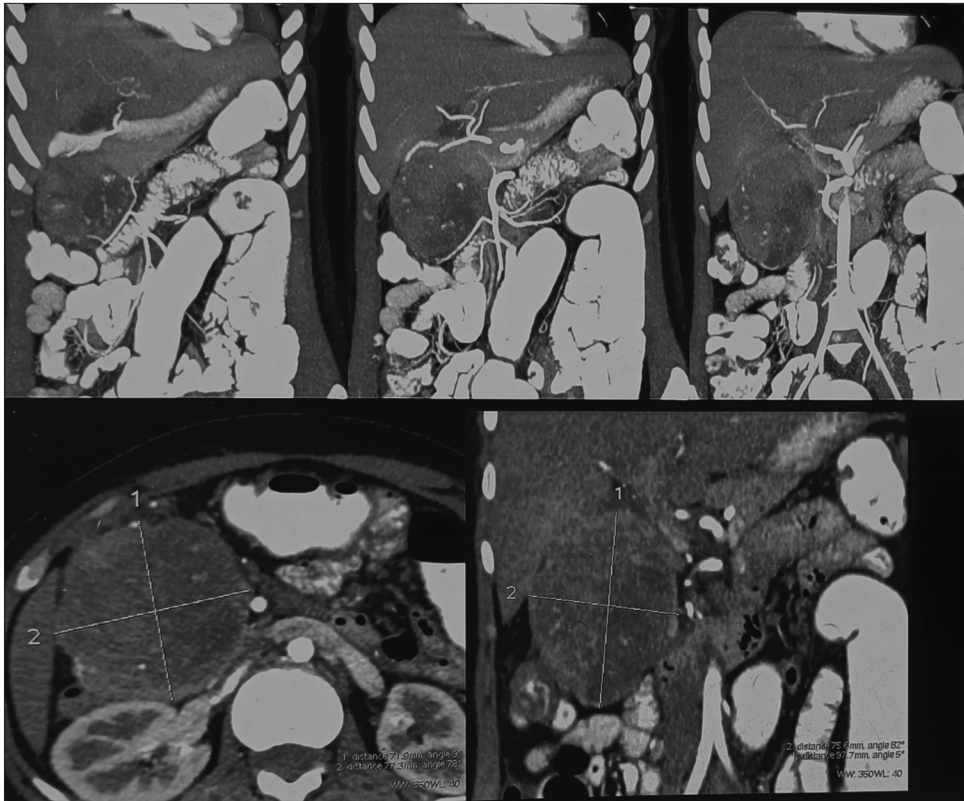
Contrast-enhanced computed tomography image, showing well-encapsulated, heterogeneously-enhancing solid mass lesion containing multiple cystic components, with multiple peripheral foci of calcification
